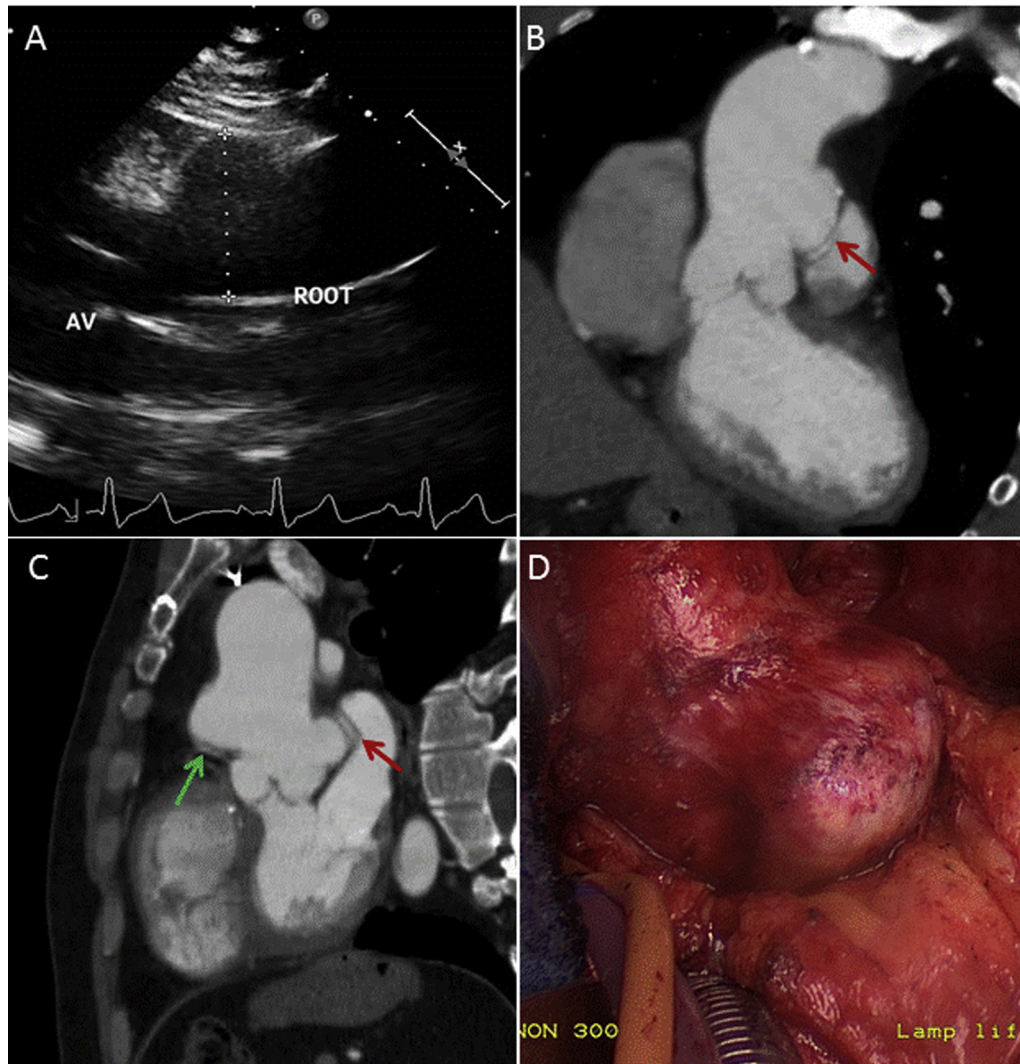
(A) Transthoracic echocardiogram parasternal long-axis view with left and right aortic aneurysms superior to the aortic root. (B) Cardiac computed tomography coronal oblique image demonstrating left aortic aneurysm with compression of the left coronary artery (red arrow). (C) Cardiac computed tomography sagittal oblique image demonstrating two aortic aneurysms with compression of the right (green arrow) and left (red arrow) coronaries. (D) Intraoperative image of the aortic root and ascending aorta prior to surgical repair. AV, Aortic valve.
